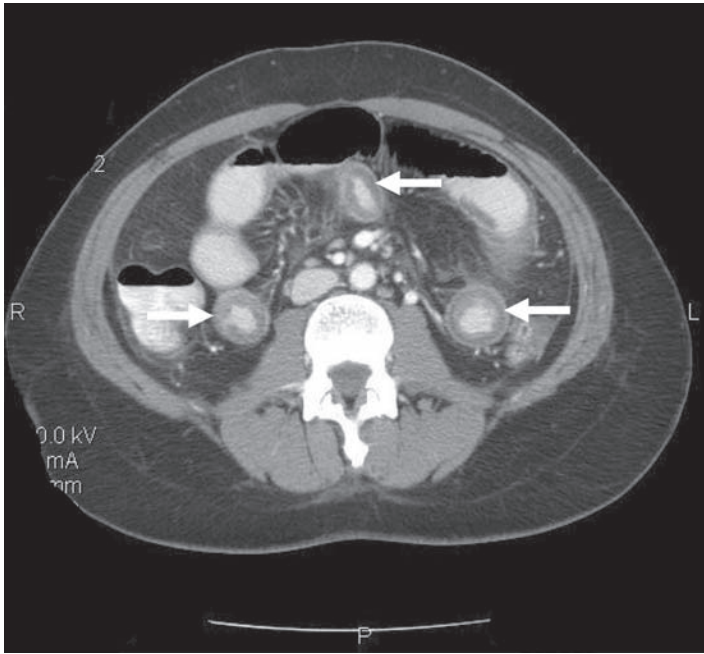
Computed tomography revealing small bowel mural thickening and submucosal edema (arrows).
